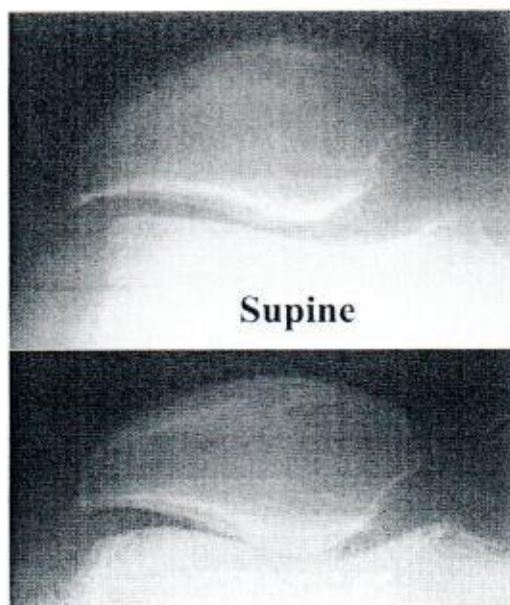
Axial radiographic views of lateral patellar arthrosis visualized in both the supine and the standing position. There is medial displacement of the patella between supine and weight-bearing
